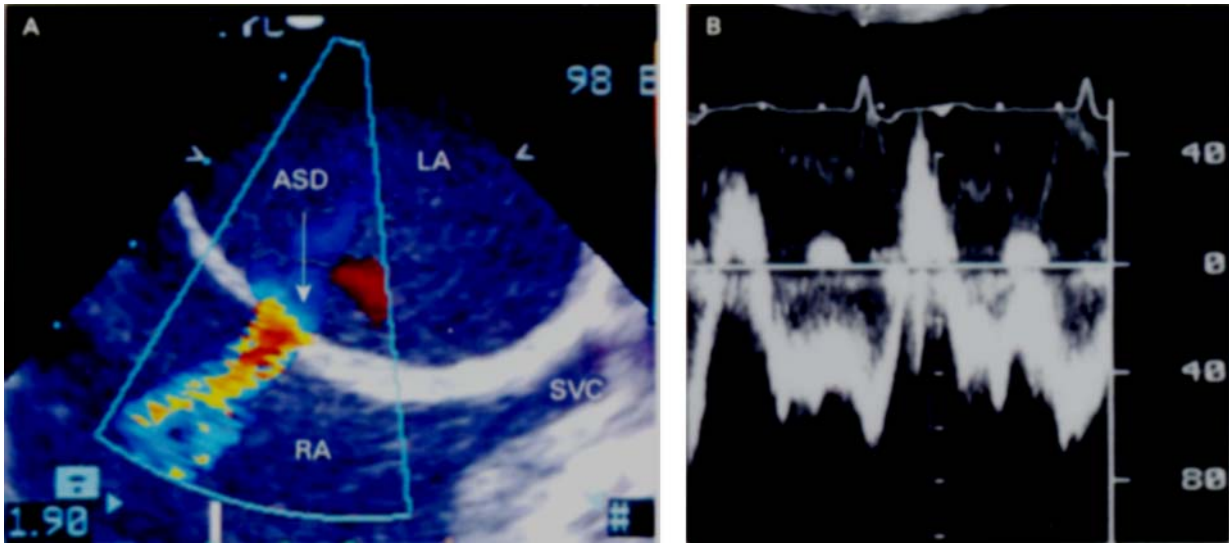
Atrial septal defect (ASD) flow. (A) Colour flow through an ASD (left-to-right shunt). (B) Pulsed wave Doppler spectral display of the ASD flow. Although the flow is predominantly left-to-right (below baseline), there are two right-to-left components (above baseline) – one during systole and one during diastole. LA = left atrium, RA = right atrium, SVC = superior vena cava.
